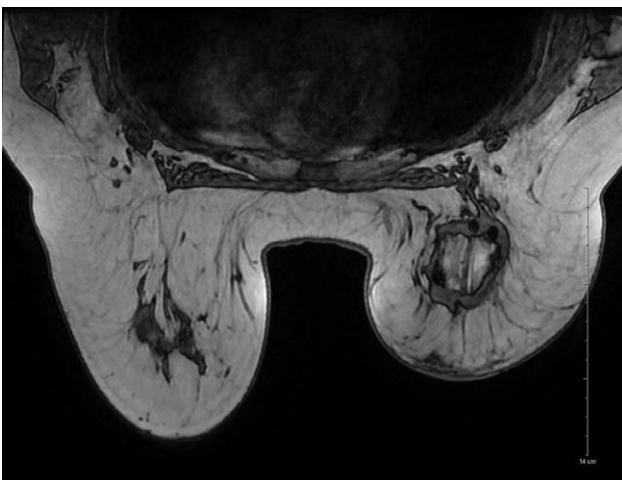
MRI of immediate patient 7, at 6 months postimplantation. Note the absence of the corpus mammae in the right reconstructed breast but the presence of vertical retinaculum, or Cooper's ligaments, running as they should, from the posterior lamellar fascia through the mesh zone into the overlying skin.
